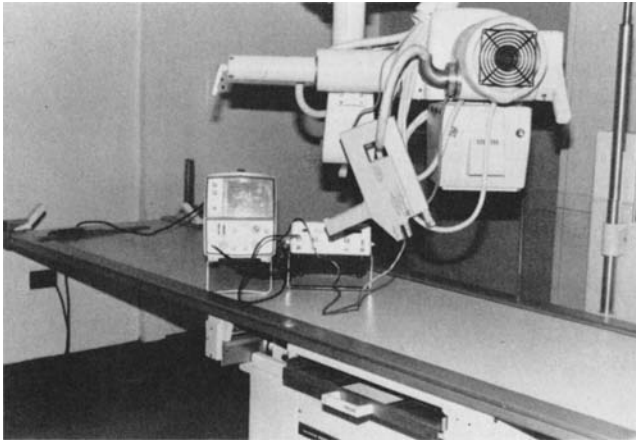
Equipment used to measure and display milliamperage of the generator. The noninvasive probe shown on the X-ray cable measures the milliamperage indirectly by sensing the induced magnetic field around the cable. The storage oscilloscope is used to display the milliamperage waveform.
